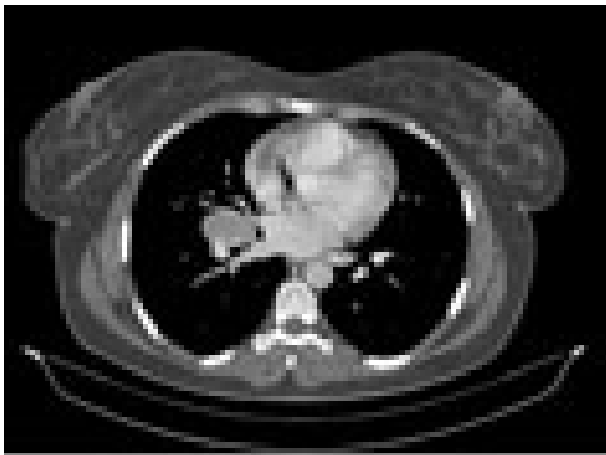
Thorax CT appearance of the lesion localized in the right hilar region.
